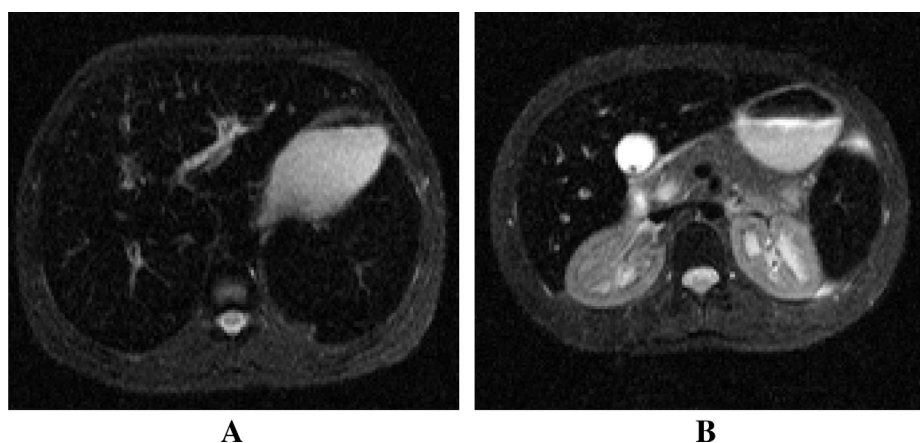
(A and B) Axial fat-saturated fast spin-echo (SE) T2-weighted MR image shows the significant hypointense signal of the liver and spleen, sparing the kidneys and pancreas, supporting diagnosis of secondary hemochromatosis.
